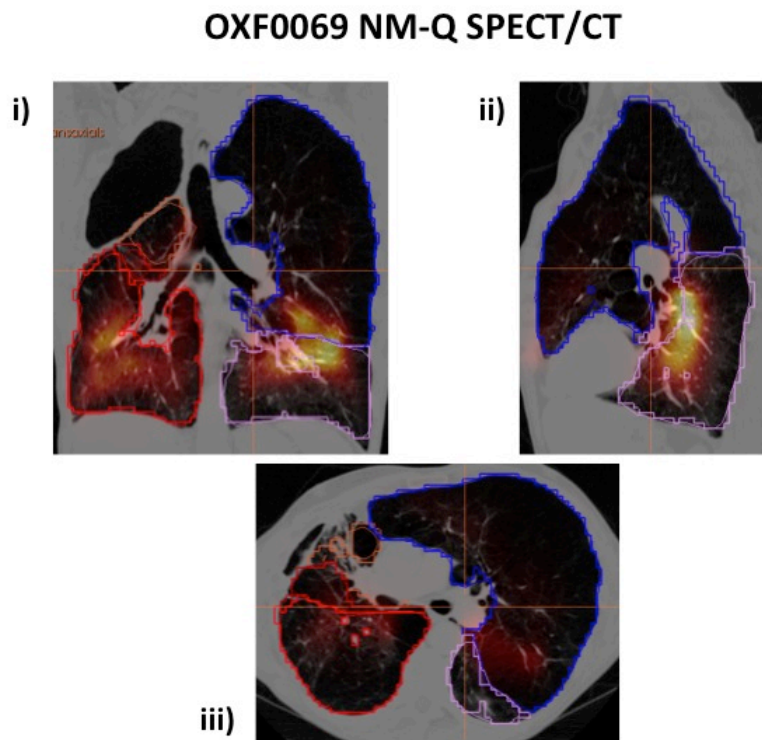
Selected NM-Q SPECT/CT images acquired from OXF0069. Images are in the i) coronal, ii) sagittal and iii) axial plane and show perfusion limited predominantly to the lower lobes.
